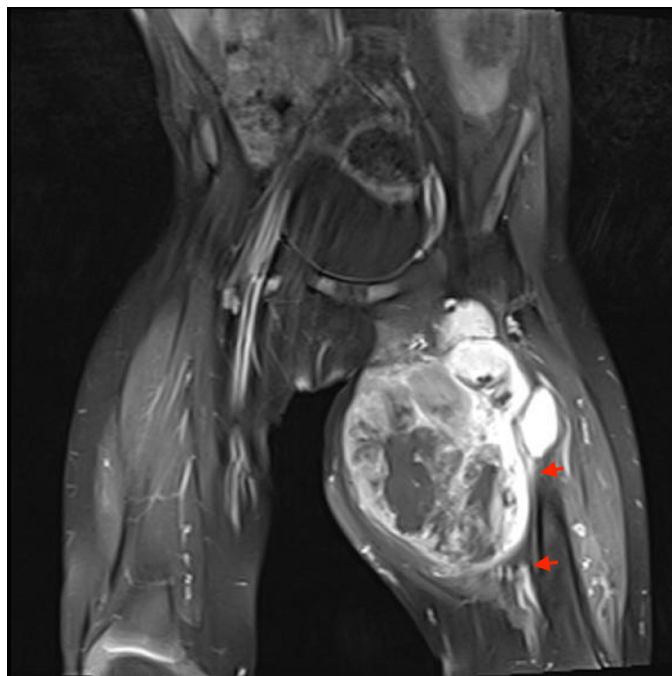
Compressed neurovascular bundle on the MRI. The arrows show the compressed neurovascular bundle
